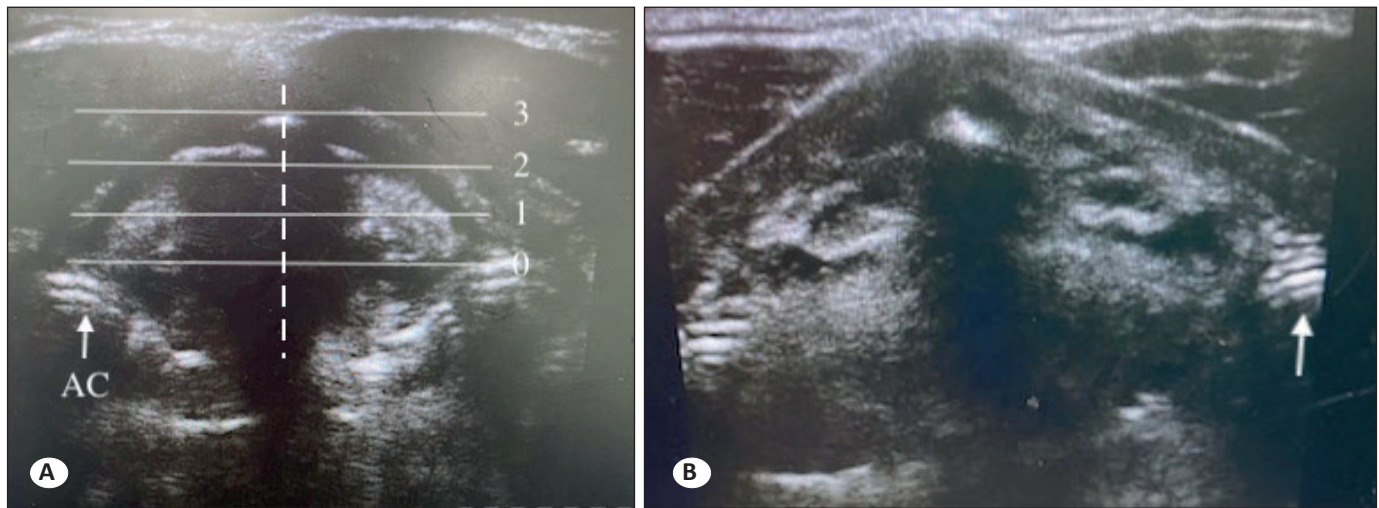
Ultrasound image of the glottis. A) The arytenoid elevation was graded from 0 to 3 in reference to the dashed lines of anterior–posterior commissure above the horizontal line of bilateral arytenoids; B) solid arrow indicates the elevated arytenoid cartilage in conjunction with the elevation of the thyroid cartilage on post-LMA USG. LMA: Laryngeal mask airway; USG: Ultrasound.
